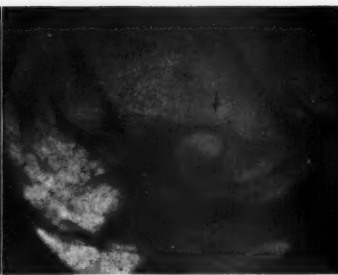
Roentgenogram of the temporal bone after the Stenvers method. Ogival (bullet-shaped) dilatation of the internal auditory canal by a nodular tumor of the auditory nerve.
